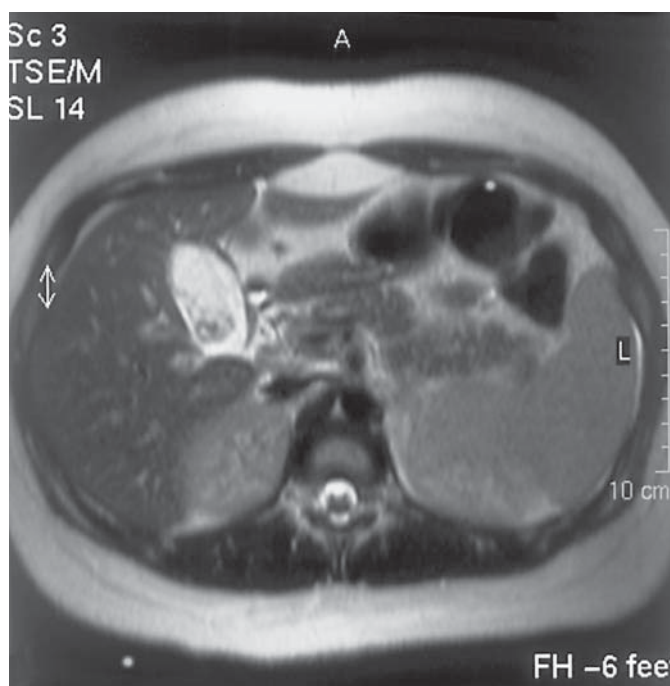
Magnetic resonance imaging revealed gallbladder wall edema, biliary sludge in the lumen of the gallbladder, perihepatic and perisplenic minimal amount ascites, decreased pancreatic gland signal and arterial capillary phase contrast enhancement of the pancreatic corpus and particularly of its tail compatible with acute pancreatitis.
